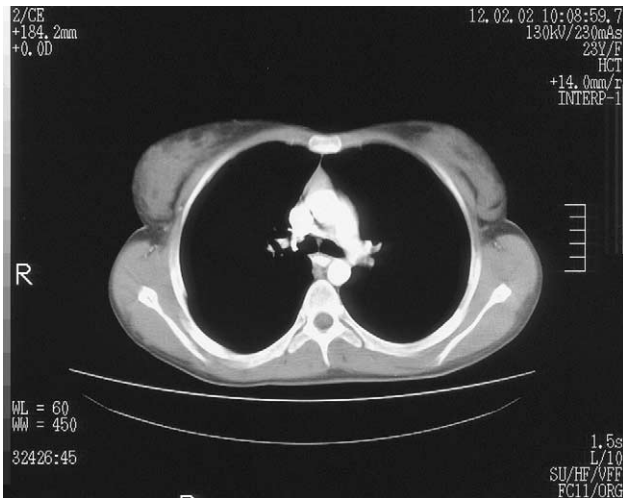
CT scan shows thymic hyperplasia.
